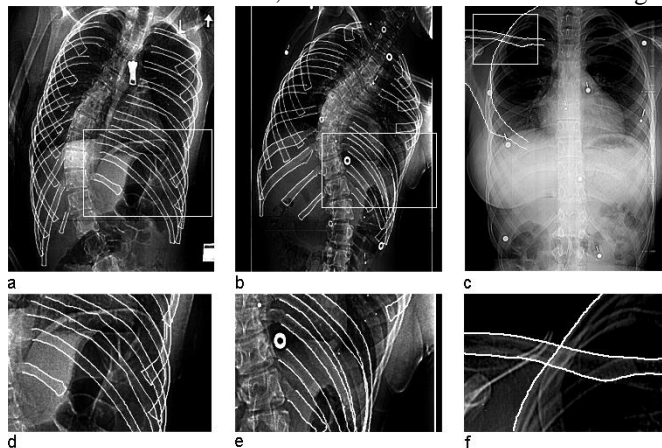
Visual detection results delineated in pure white. (a,b) Two chest radiographs of scoliotic patients classified as ‘good’ and ‘poor’. c) Missed rib case for rib L4. (d,e) Zooms on details of figures 15a and 15b respectively. f) Zoom on details of figure 15c. White rectangles are zoomed areas.
